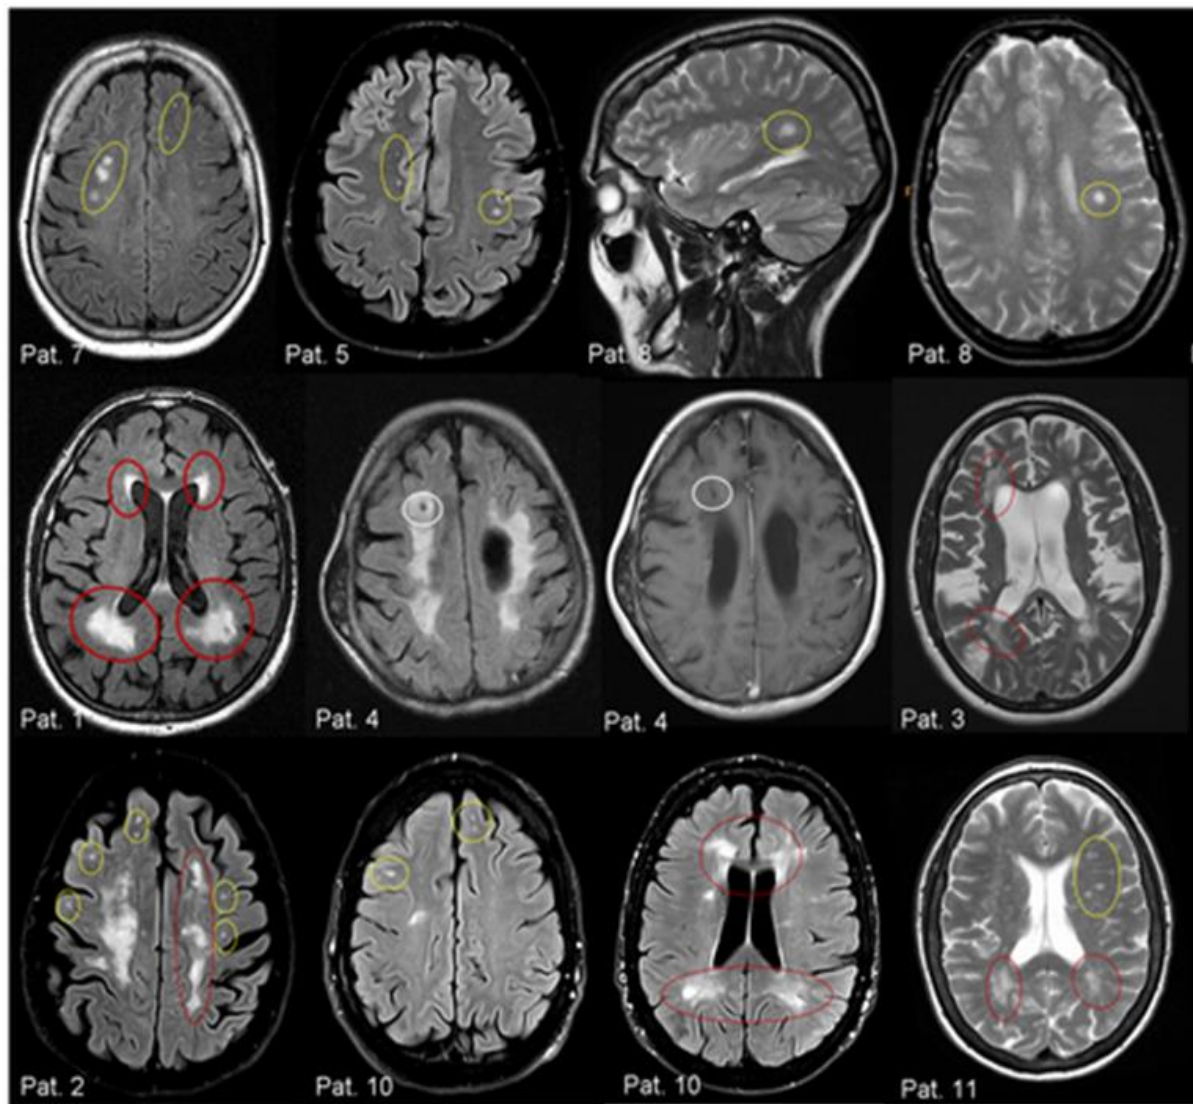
MRI showing WMLs secondary to Fabry disease in patients misdiagnosed with MS.
